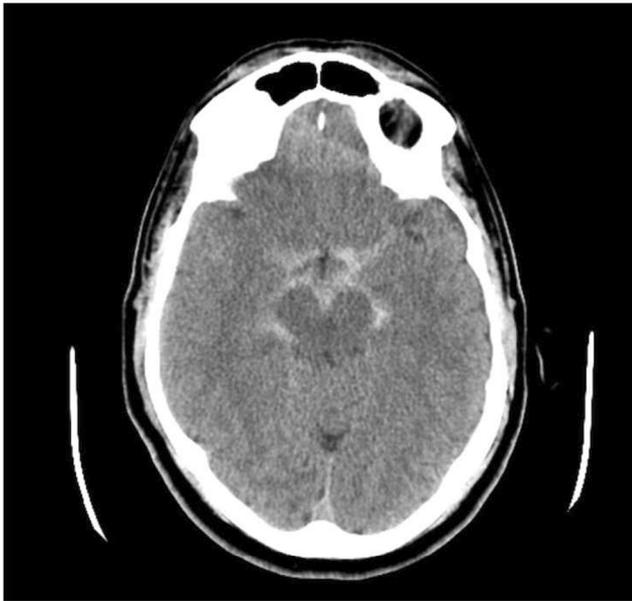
Head CT scan performed at onset showing SAH in a perimesencephalic distribution
